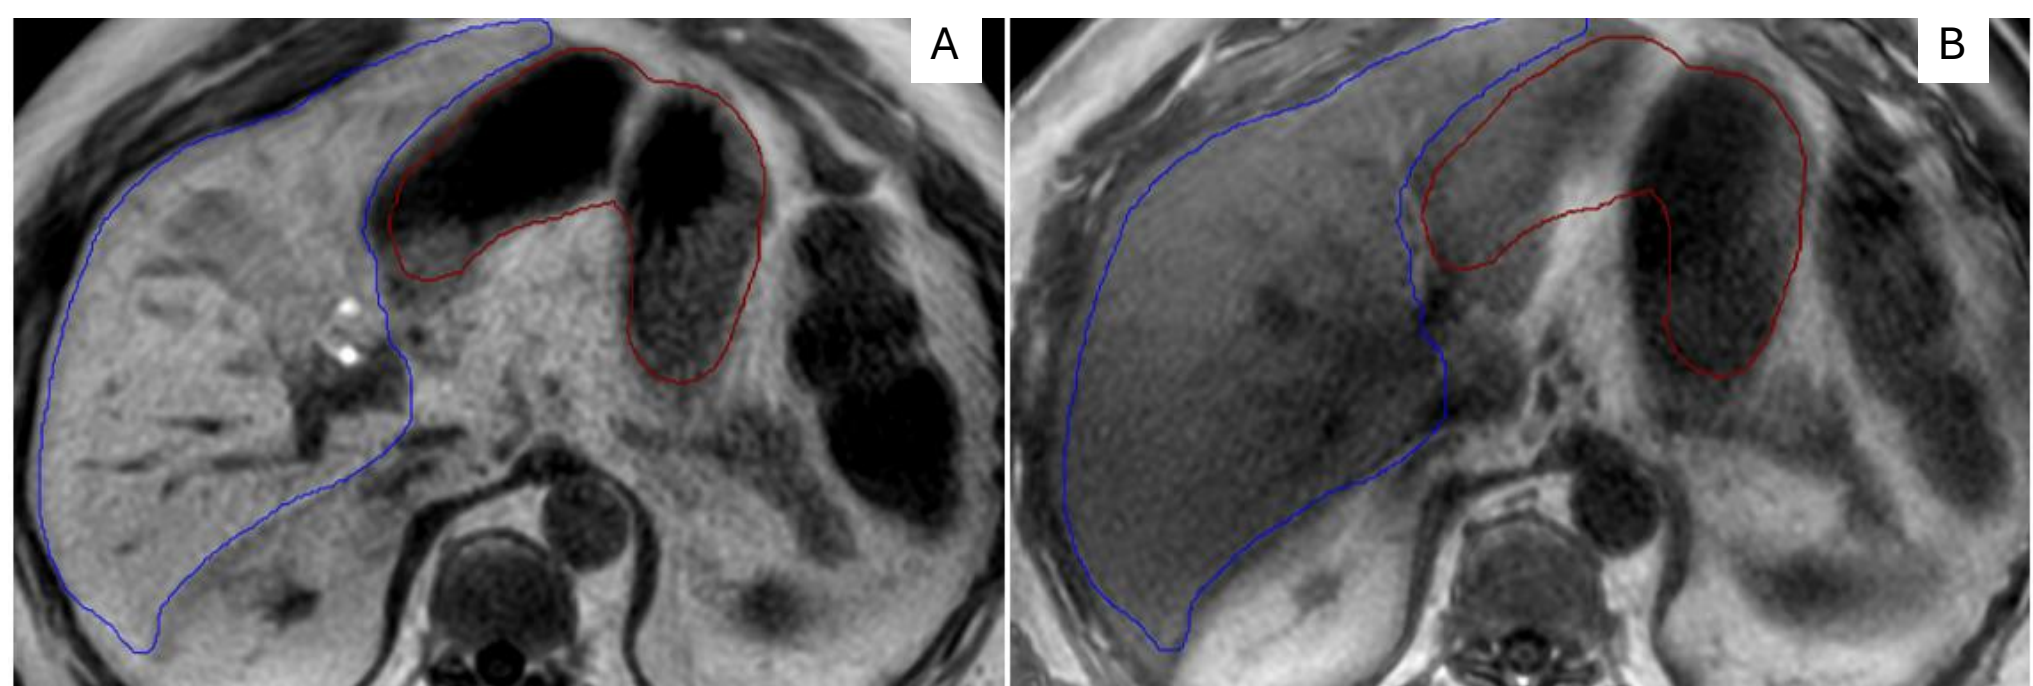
(a-b): Axial MR images acquired on consecutive treatment days demonstrating inter-fraction anatomical variation in the stomach (red) relative to the liver (blue).
